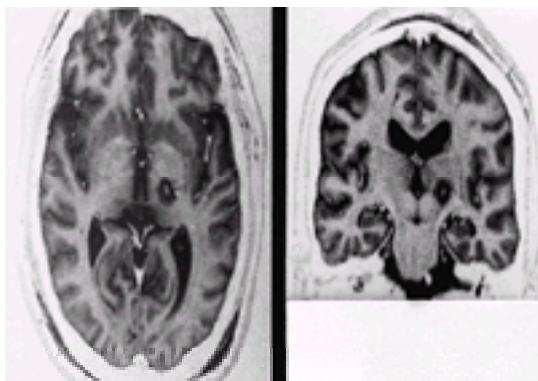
Axial and coronal MRI of the brain, obtained 4 h after ventralis intermedius thalamotomy. Fast spin echo inversion recovery sequence: TI, 200 ms; TR, 2000 ms; TE, 24 ms; slice thickness, 2.0 mm. There is a ring of edema (black) around the coagulum of the lesion (white). The corticospinal tract is lateral to the lesion.
